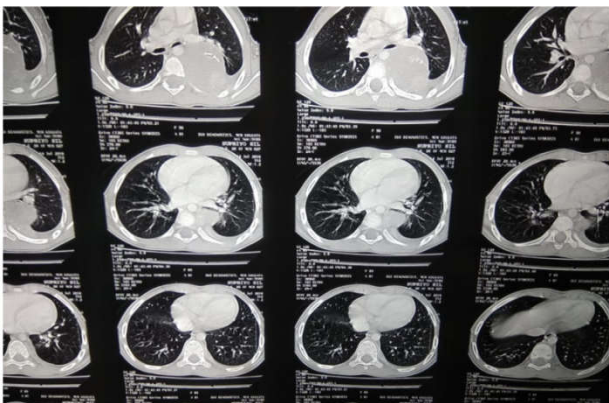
Contrast Enhanced CT chest showing mediastinal mass
